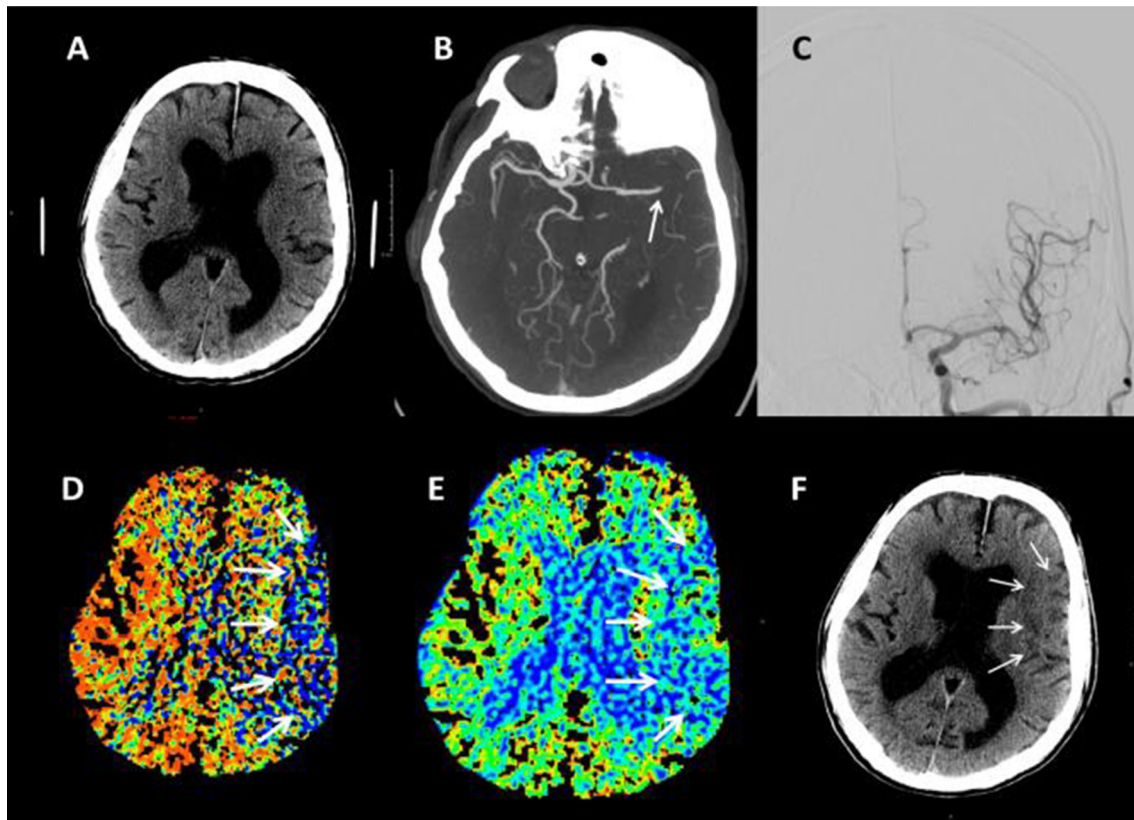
A 82-year-old male with type 2 diabetes mellitus and chronic hypertension was brought to the emergency department because of *right-sided* hemiparesis. NCCT revealed minor ischemic changes (ASPECTS = 9, only one level shown, A). There was an occlusion of the *left* distal M1 segment in CTA (B). CBV-ASPECTS was scored 7
